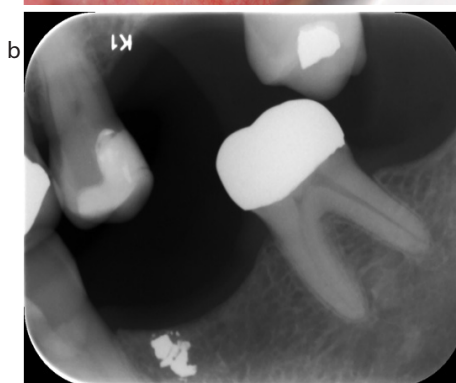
(a) An amalgam tattoo presenting as a localized, flat area of slate-grey pigmentation on the gingivae. (b) Intra-oral radiograph revealing a radio-opacity consistent with amalgam.
